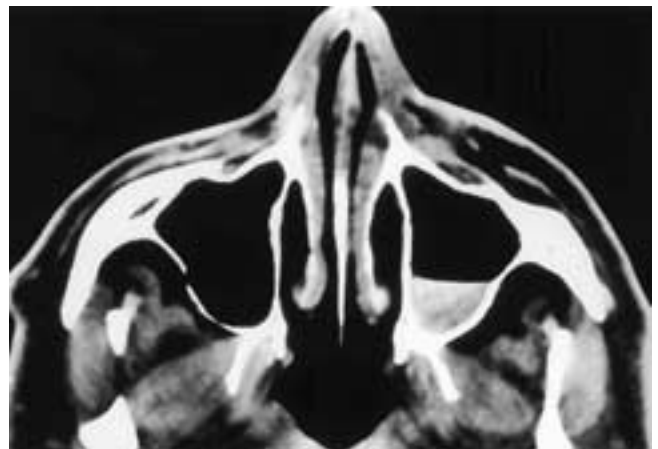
Axial CT scan shows an air-fluid level in the left maxillary sinus. The fluid is dense compared to water attenuation (see Figs. 5-5 and 5-6) in this patient, who had received blunt facial trauma. This patient had sinus hemorrhage.
